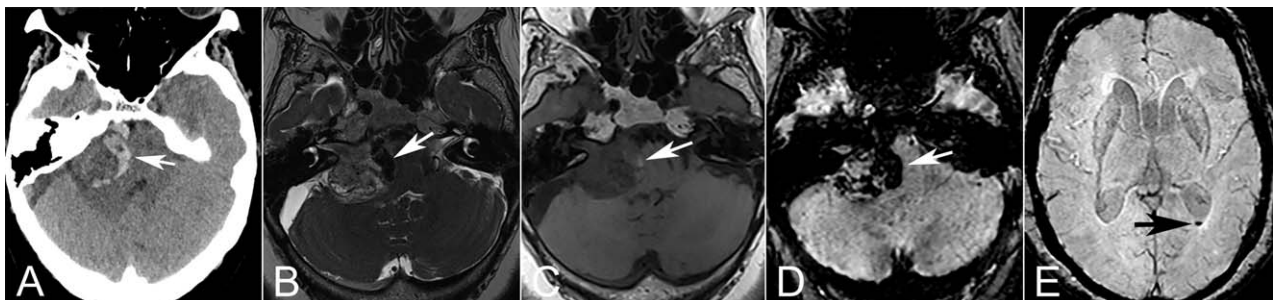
A 72-year-old woman with hypertension presented with acute headache, nausea, vomiting, and lower extremity weakness. (A) Axial noncontrast computed tomography shows crescent-shaped intratumoral hemorrhage on medial aspect of VS (arrow). (B) Axial 3D T2 fast spin echo image demonstrates marked T2 hypointensity (arrow) along the medial margin of the large VS consistent with hemorrhage. (C) Axial 3D T1 fast spin echo image demonstrates punctate focus of T1 hyperintensity (arrow) consistent with hemorrhage. (D) Axial SWI demonstrates extensive hypointense signal (arrow) confirming presence of hemorrhage identified on T2 and T1 sequences. (E) Axial SWI image at level of the atria of the lateral ventricles demonstrates layered intraventricular hemorrhage (arrow). 3D = three-dimensional; SWI = susceptibility-weighted image; VS = vestibular schwannoma.
